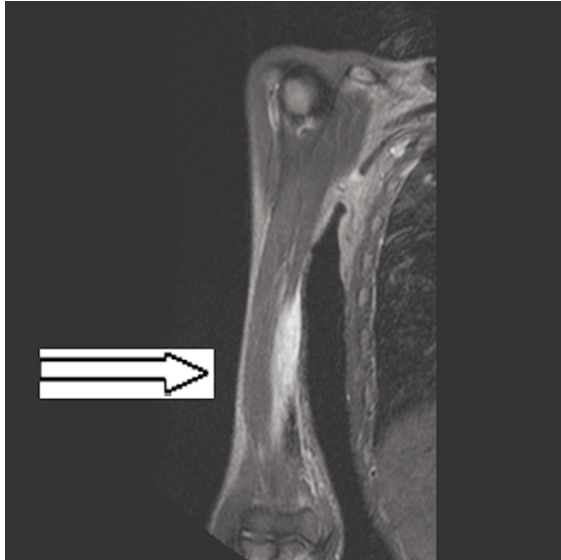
T1 IRTSE coronal magnetic resonance image showing biceps brachii tear and hematoma.
